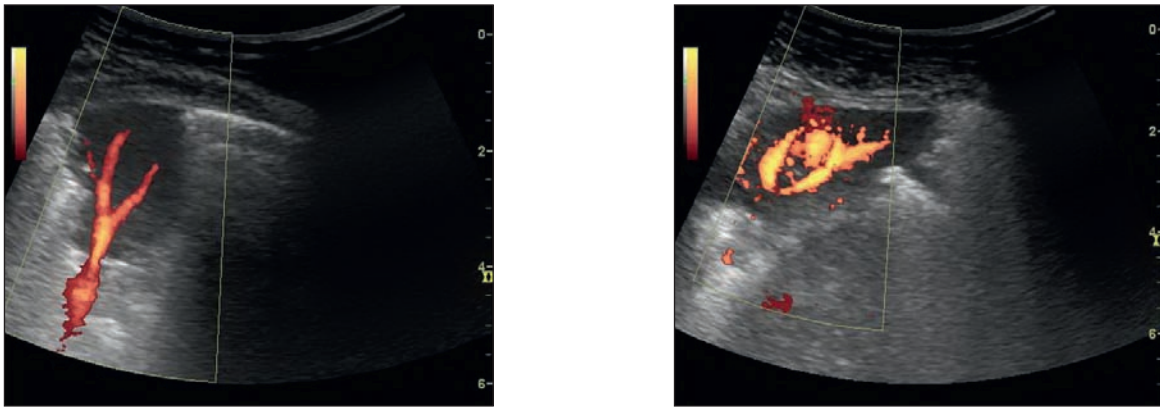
Ultrasound image of blood flow in the lung consolidate. Doppler blood flow analysis in the energy scanning mode shows increased vascularization, regular vascular pattern (from the personal archive of G.V.Nekludova)
